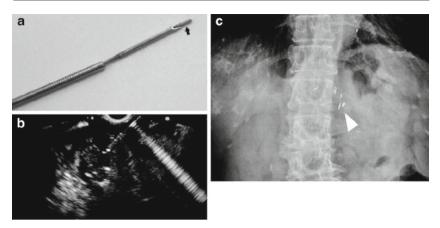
(a) An iodine-125 radioactive seed (arrow) at the tip of an echoendoscope needle. (b) EUS-guided implantation of seeds in the pancreas. (c) Brachytherapy seeds visible on a radiograph (arrow head).
